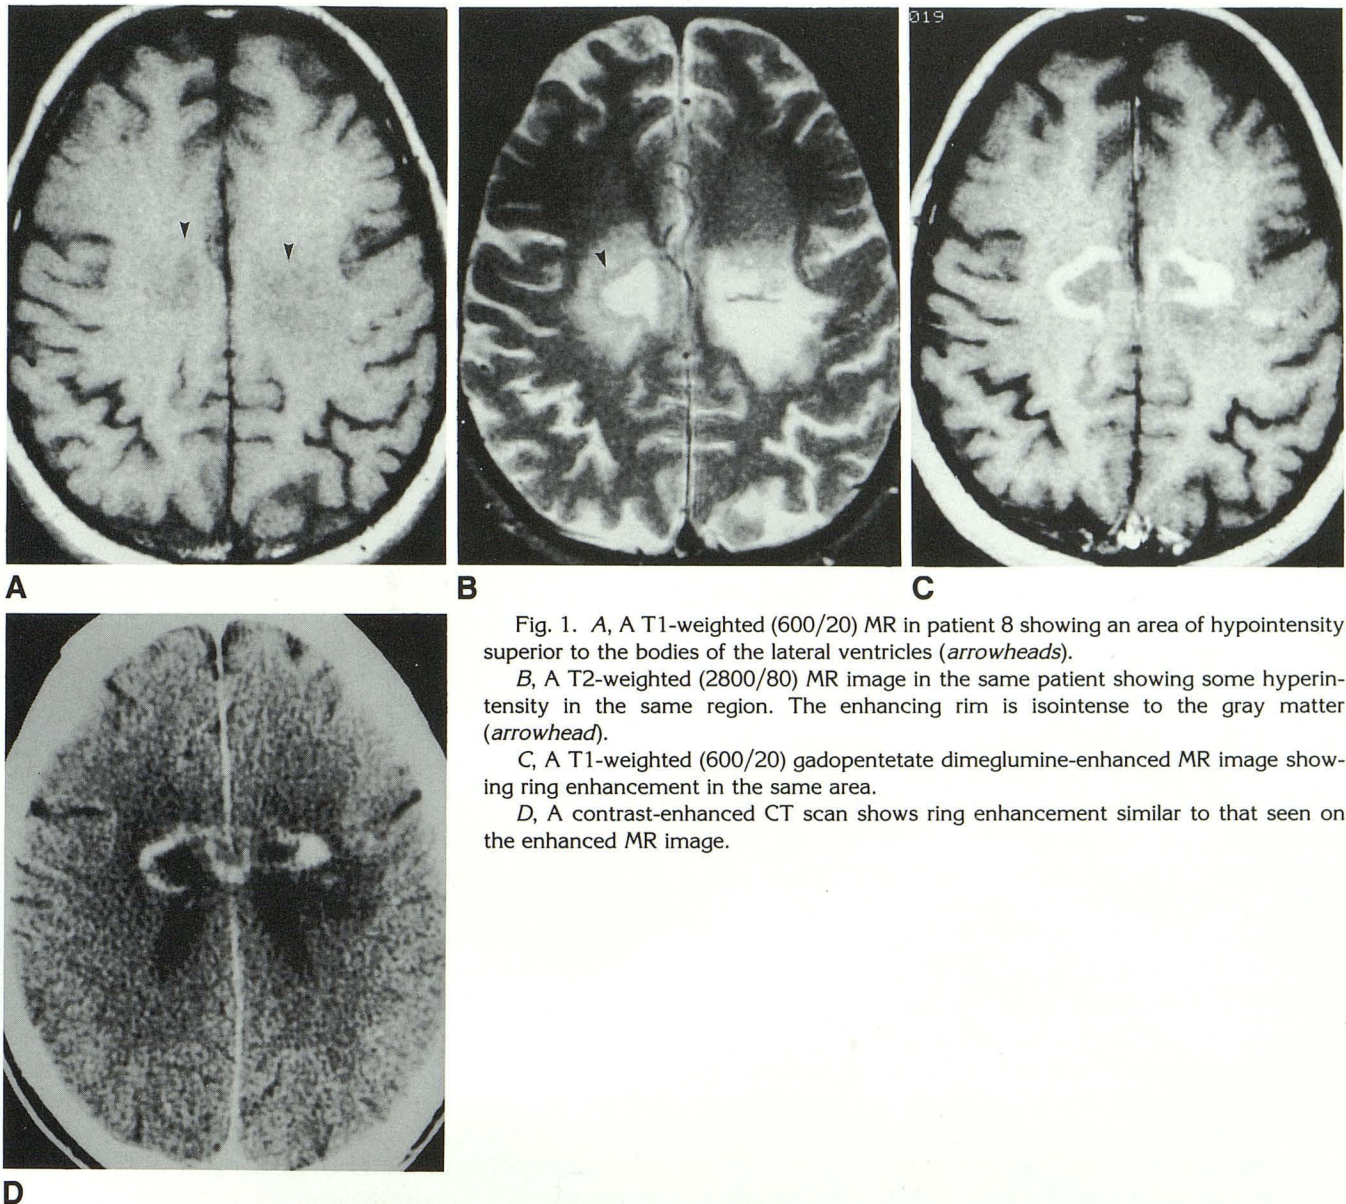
A, A T1-weighted (600/20) MR in patient 8 showing an area of hypointensity superior to the bodies of the lateral ventricles (*arrowheads*).
